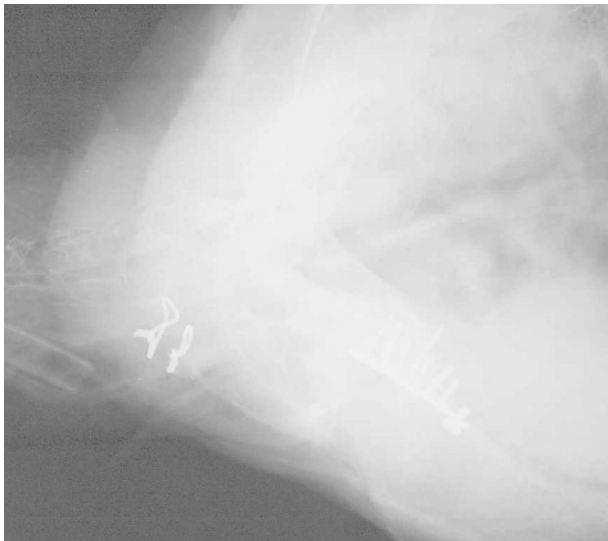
Lateral radiographic view of the eagle described in Figure 1, showing surgical repair of the left coracoid luxation with a T-plate, a compression plate, and cerclage wires.
